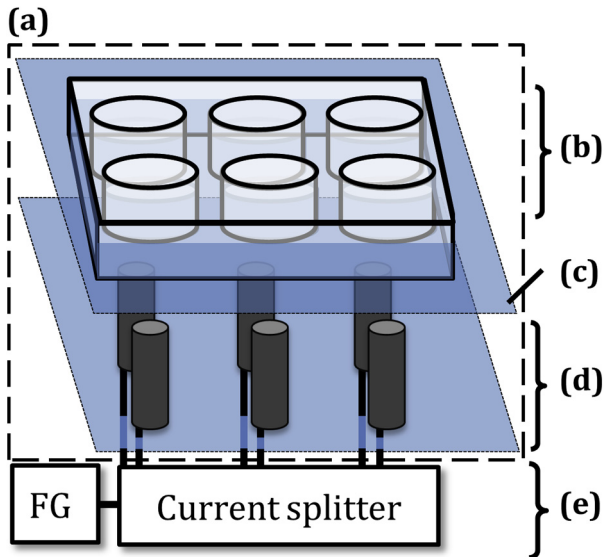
Typical sonobioreactor setup. (a) The entire setup, excluding electrical components, is kept in an incubator with temperature and oxygen controlled. (b) Cell seeded scaffolds are placed in the wells of a tissue culture plate; each well contains growth medium. Tissue culture plates can contain 6, 12 or 24 wells. (c) The tissue culture plate is partially submerged in an aquarium so that no air bubbles exist below the tissue culture wells, while the culture medium is kept isolated from the aquarium. The aquarium acoustically couples the wells to the ultrasonic transducers. (d) An ultrasonic immersion transducer is placed below each of the tissue culture wells to provide mechanical stimulation (bottom-up sonication). Alternatively, the transducers may be placed directly above the tissue culture well, partially immersed in the culture medium, for top-down sonication. (e) A function generator (FG) and current splitter provide the voltage input to each ultrasound transducer. The input is sinusoidal with variable frequency and voltage amplitude.
